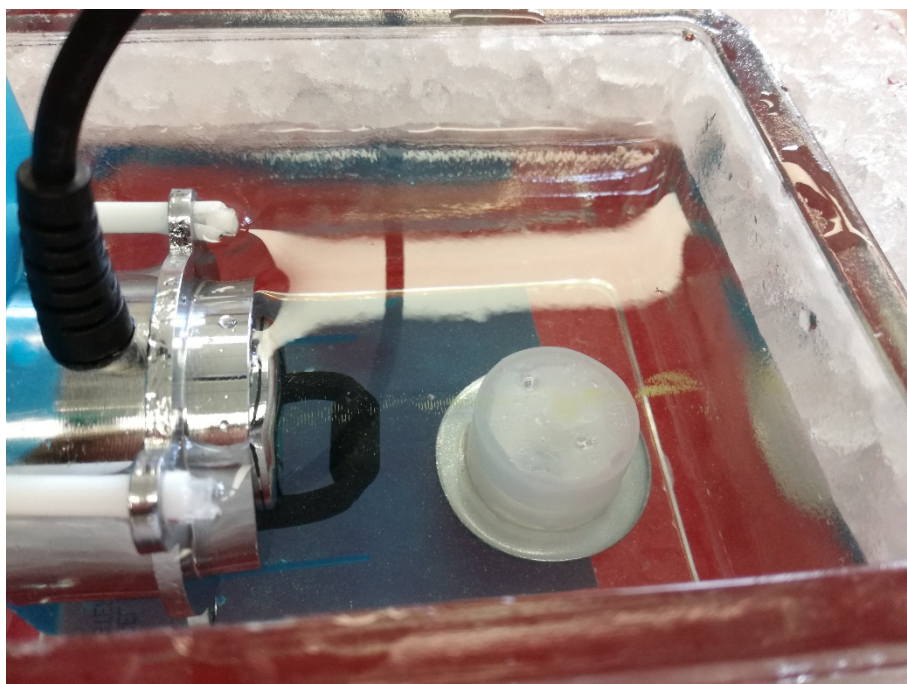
An ultrasonic humidifier used for sonicating tissue in a standing wave setting. DAPI-aggregates (yellow cloud in the buffer) and aligns in the pressure nodes of the sonication field.
